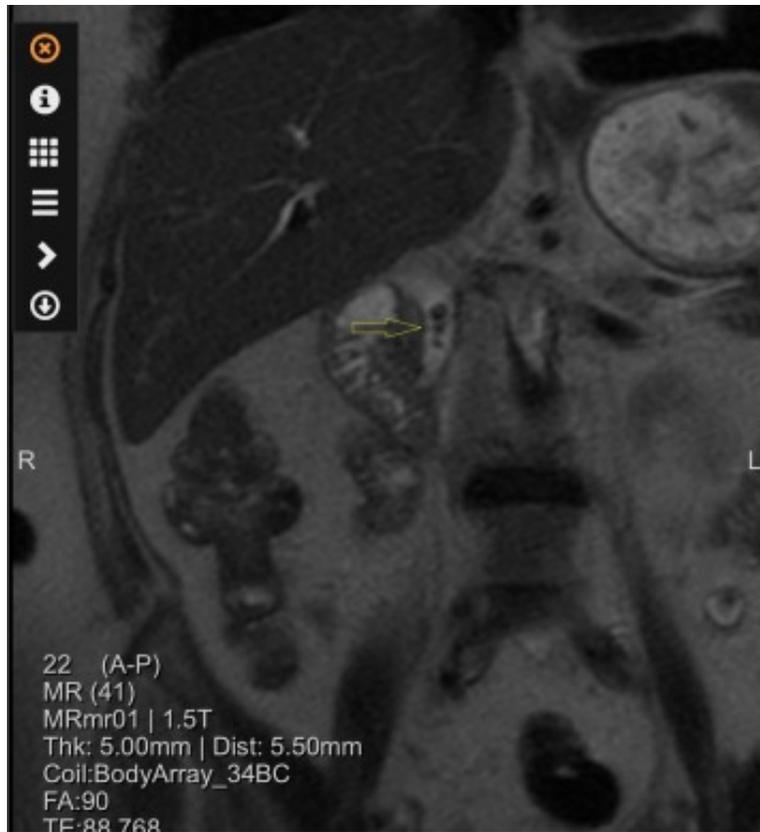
Cholangio-MRI – multiple choledocic lithiasis (yellow arrow).
